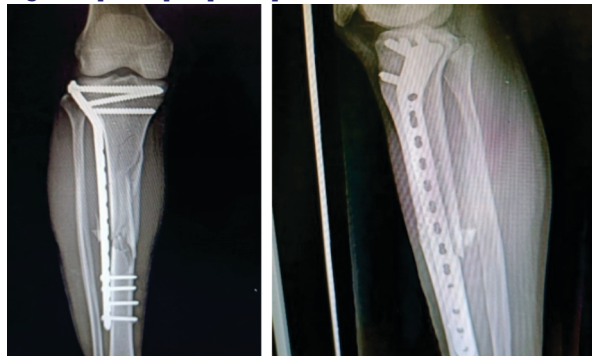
Post-op 1 month xray
